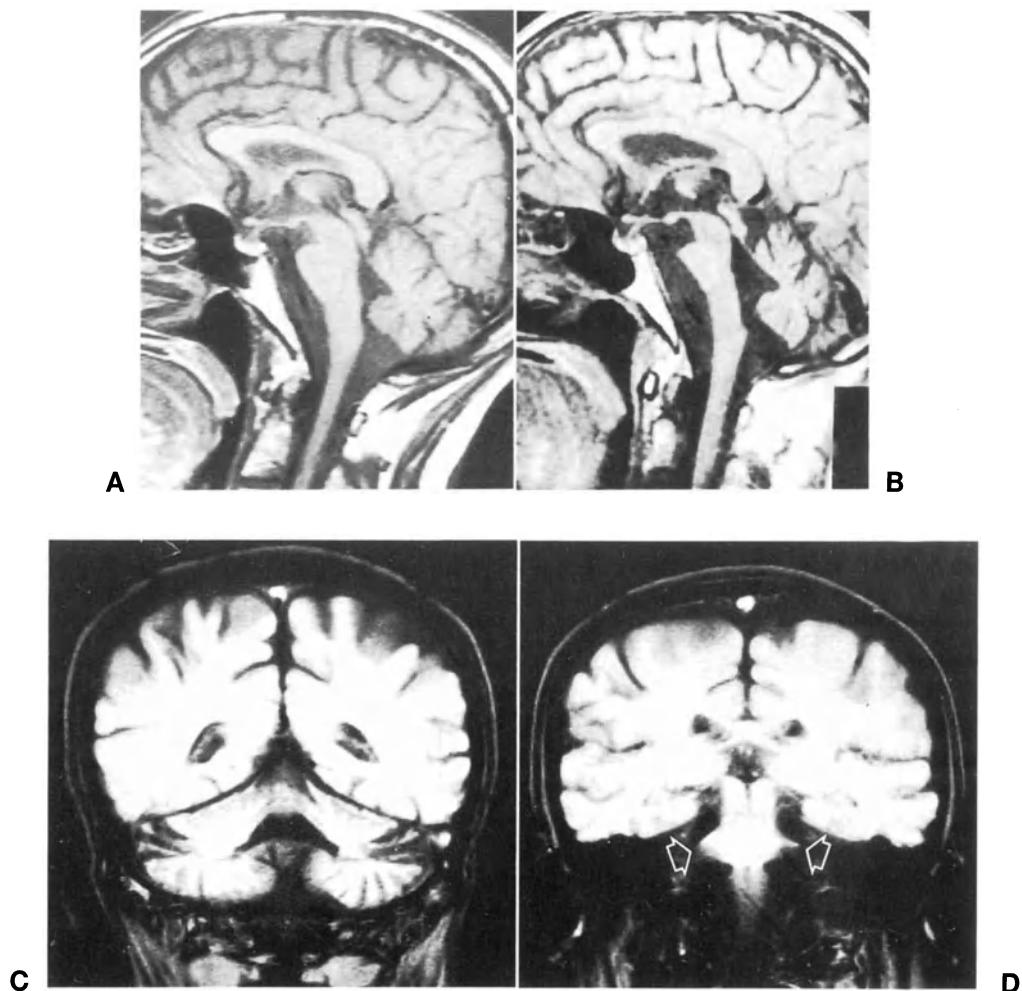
Olivopontocerebellar atrophy. Early in the course of the disease, clinical and MRI findings may remain uncertain; note minimal flattening of the inferior part of the profile of the pons in A. Three years later, with clinically advanced disease, the atrophy of the pons and cerebellum is unquestionable (B) (both A and B, sagittal T1-weighted sections). T1-weighted coronal sections on the cerebellum (C) and pons (D) in a different patient demonstrate atrophy of the cerebellar hemispheres and of the middle cerebellar peduncles (open arrows)
